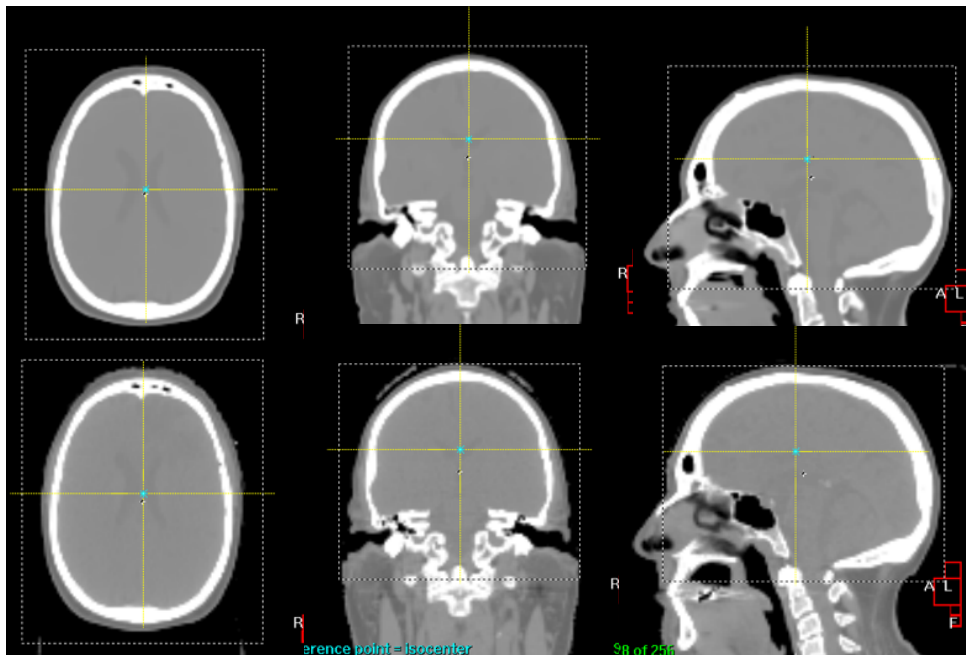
Example of image registration clipbox positioned on a reference, sCT (top row) and CT (bottom row) images for a brain patient in XVI (Elekta). The axial slice in (left), coronal (middle), and sagittal (right).
